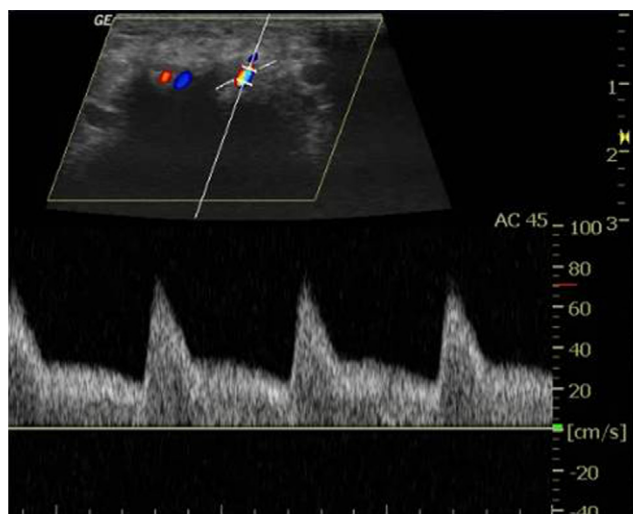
Penile color Doppler waveform analysis (in the rigid phase) performed 15 minutes after intracavernosal pharmacologic stimulation with prostaglandin E_1 . The peak systolic velocity is > 25 cm/s, which reflects the integrity of the arterial dilation, and the persistent EDV is > 5 cm/s, which reflects low resistance. Both of these measurements are diagnostic criteria for VOD.
